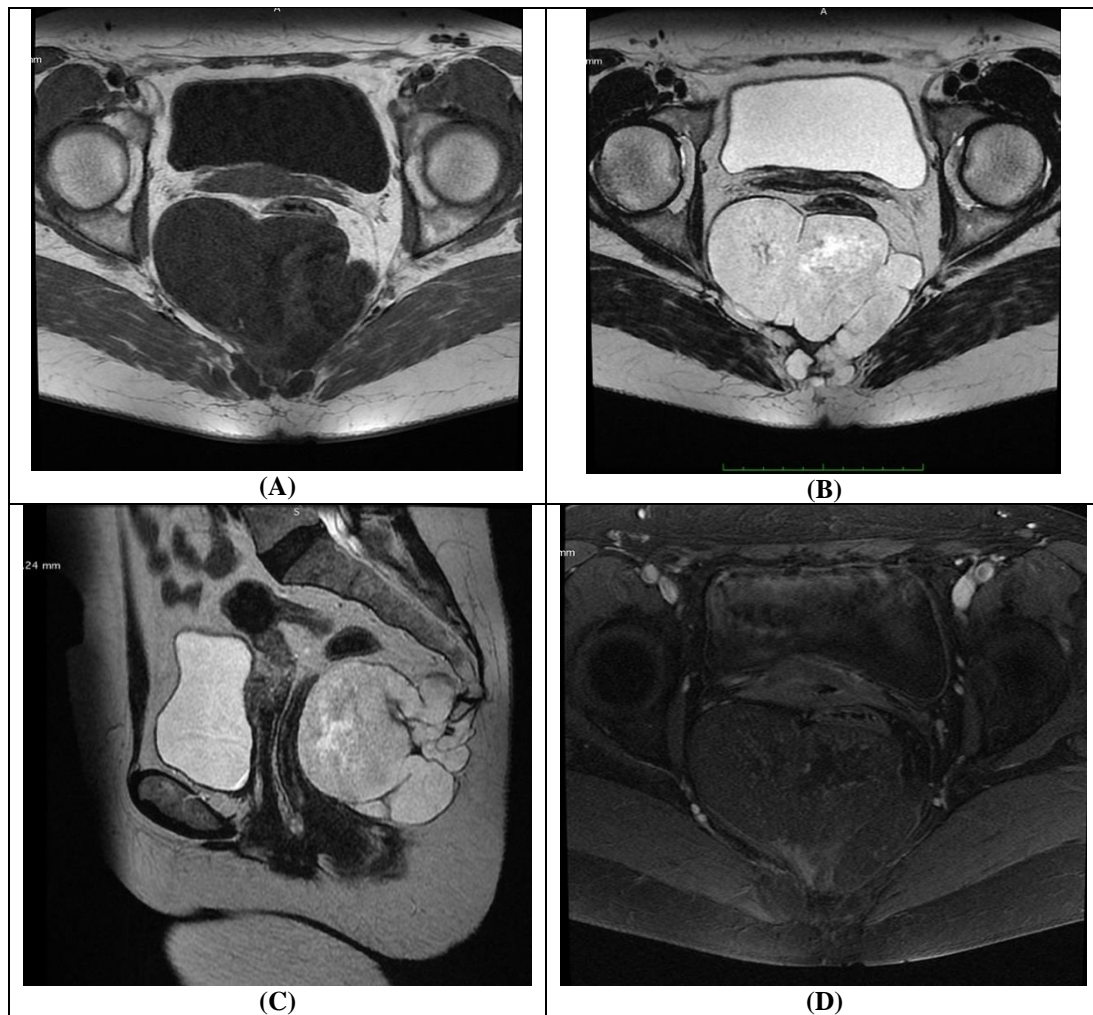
Magnetic resonance imaging (MRI) of the pelvis was performed without and with contrast; (A) axial T1, axial (B) and sagittal T2 (C) and post-contrast T1-weighted images (D) demonstrate a well-defined soft tissue mass involving the distal sacrum and coccyx, with extension into the retrorectal space and dorsal soft tissues. The mass is hypointense T1 (A), and hyperintense on T2 sequences (B, C) with linear hypointense septa, revealed heterogeneous enhancement
